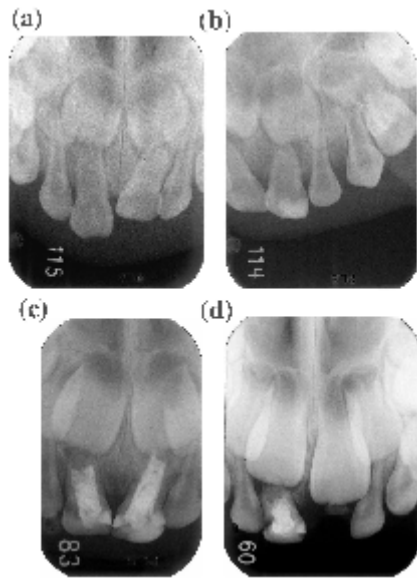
Initial radiograph (a) (1y11m, male) A radiograph at 4 months after the injury (b) A radiograph at 1 year 10 months after the injury (c) A radiograph at 4 years and 2 months after the injury (d)
